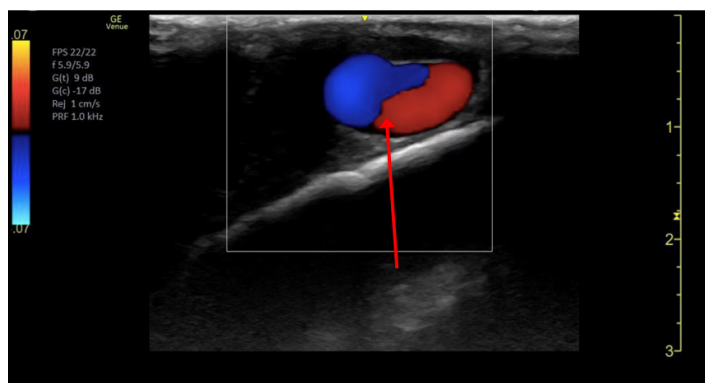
Color Doppler ultrasound demonstrating internal swirling blood flow within the lesion consistent with pseudoaneurysm ("yin–yang sign").
